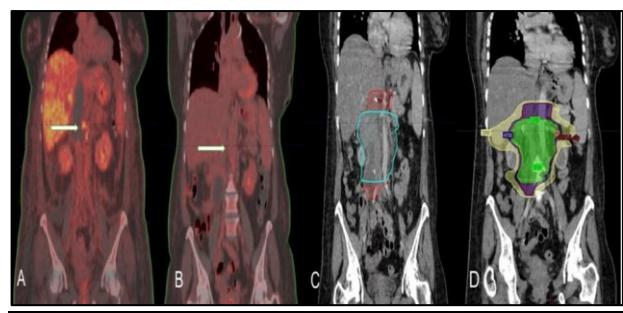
Coronal views: A) pre-operative PET CT scan (white arrow showing FDG uptake), B) post-operative PET CT scan (absence of FDG uptake), C) treatment volume, D) dose distribution (Yellow: 50% isodose of total dose, 3000cGy; blue: 95% isodose of total dose, 5700 cGy; green:95% isodose of phase I, 4750cGy).
